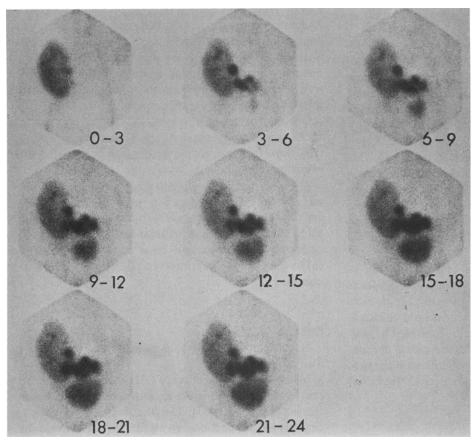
Sequential scintigrams show urinoma localized between pelvis and urinary bladder. Postvoid scintigram (not shown here) demonstrates emptying of bladder and retention of activity in urinoma.
